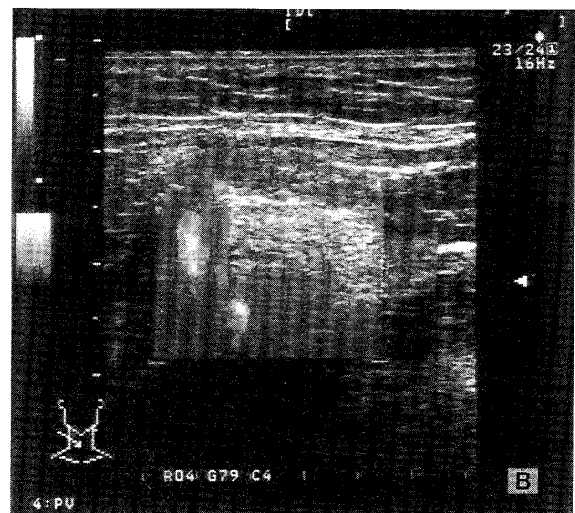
Power mode Doppler image obtained with an oblique sagittal orientation parallel to mandibular plane show intraparenchymal arteries.
